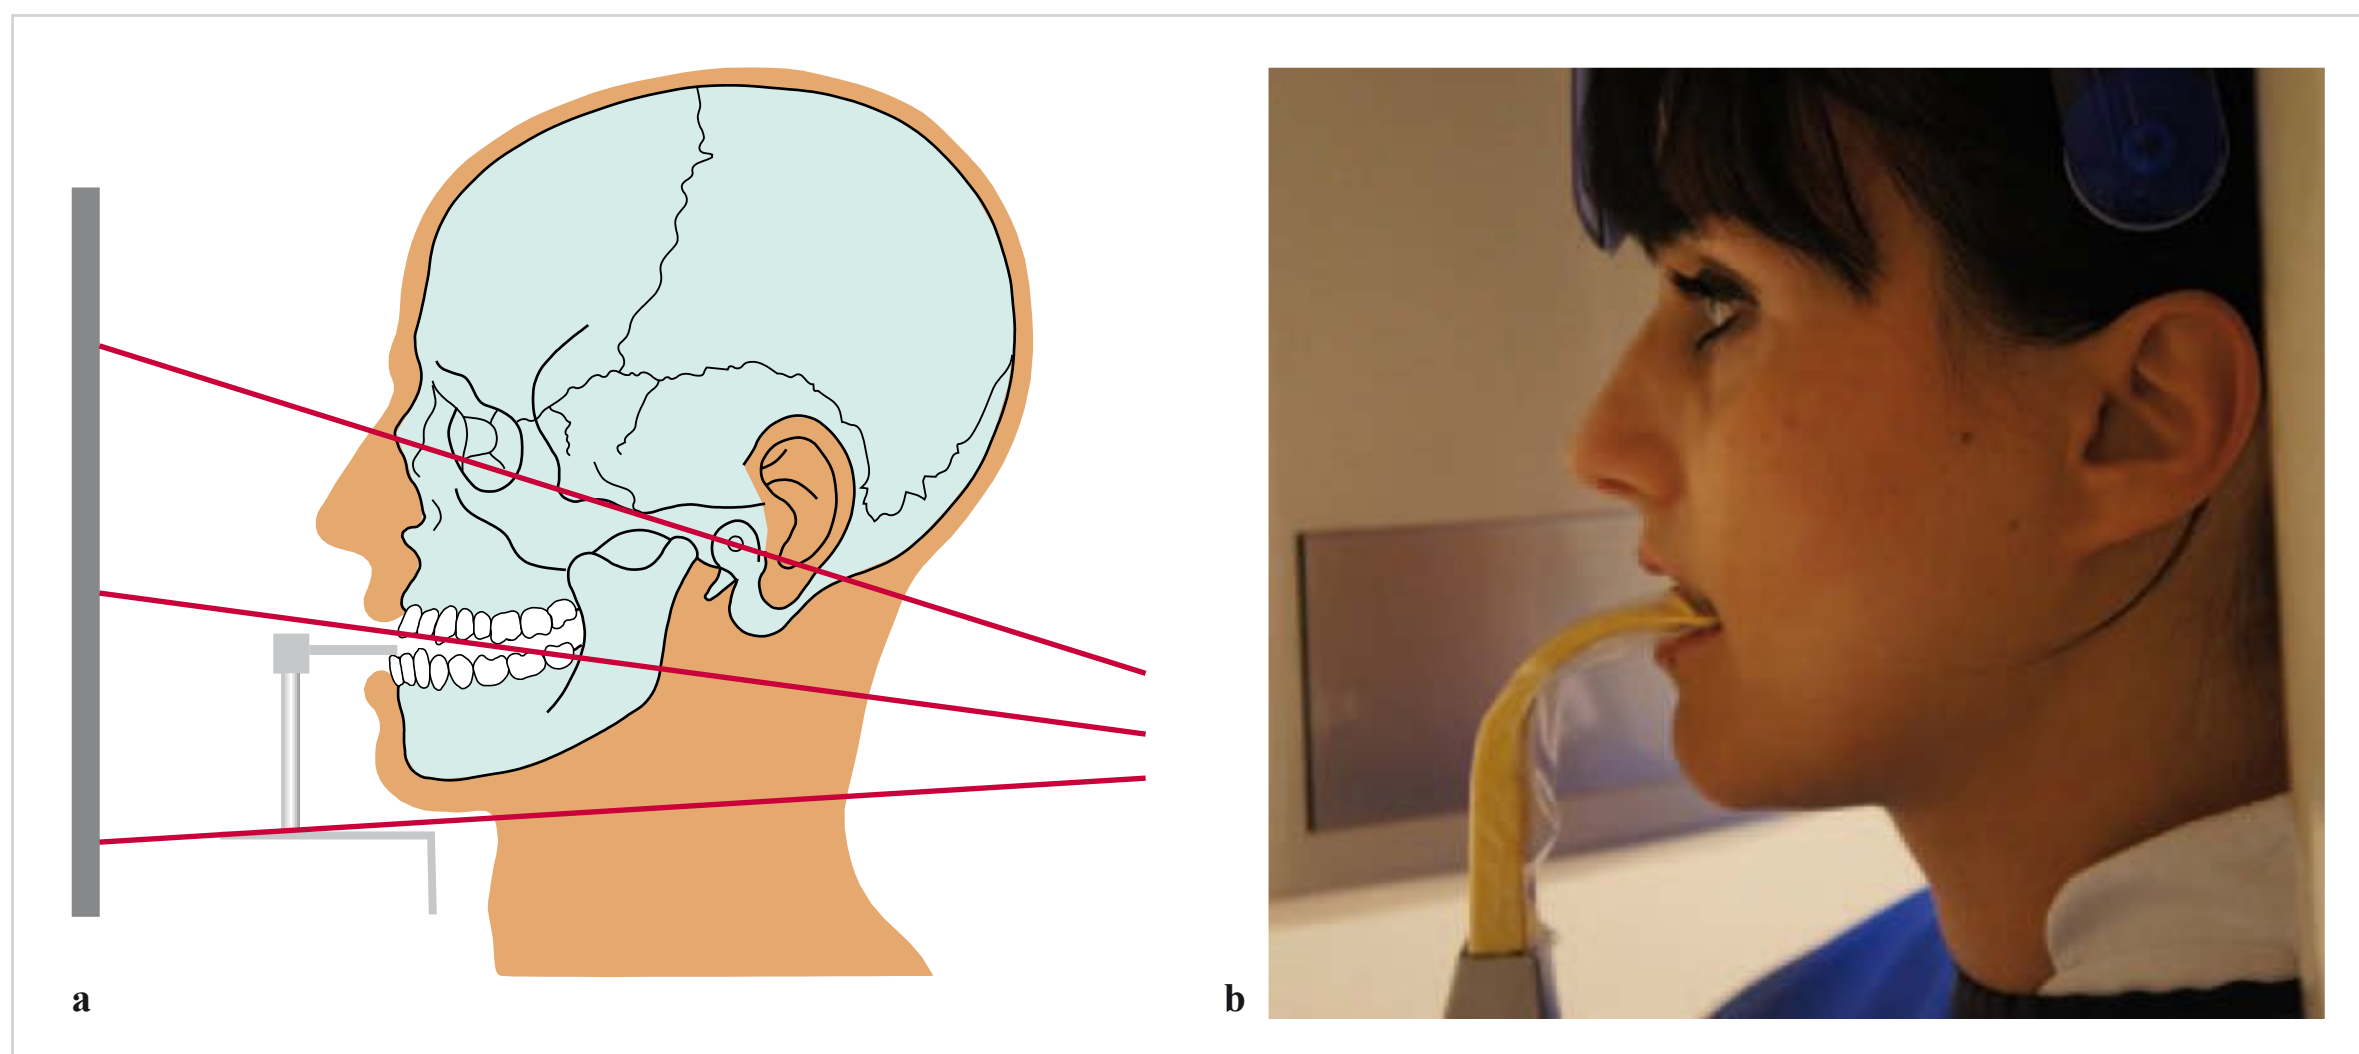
a, b Projection geometry and head positioning in panoramic radiography.
